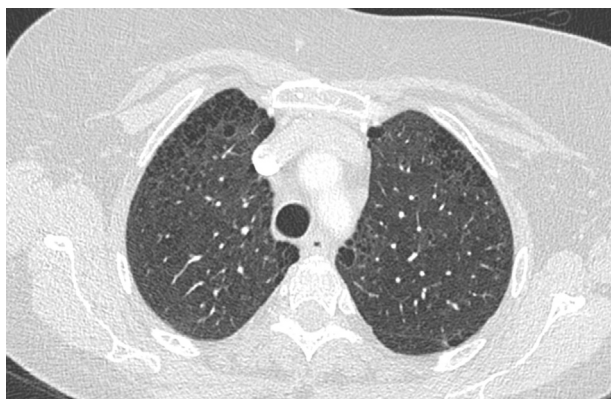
HRCT of the chest revealing bilateral cystic lesions.
